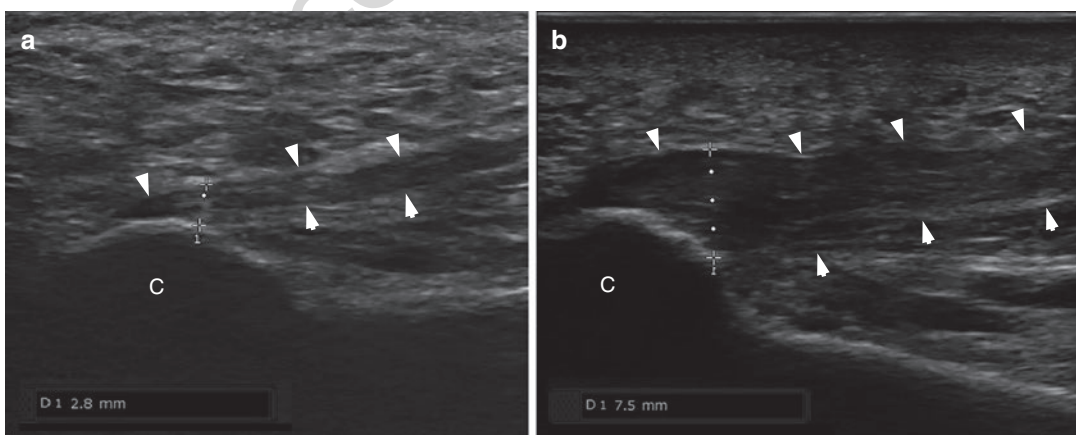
Ultrasonography of normal (a) and abnormal case (b) c indicates a calcaneus and the arrow heads indicate a plantar fascia. The thickness of the proximal plantar
